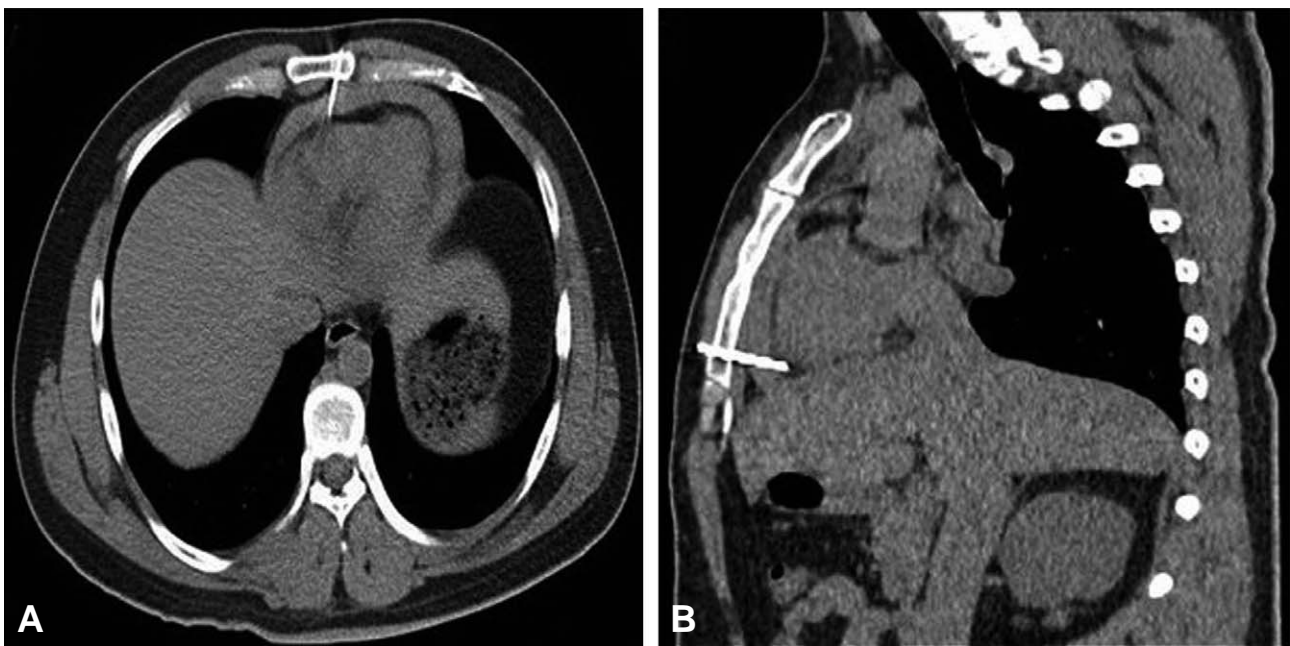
Noncontrast CT scan of the chest, axial source image (A) and sagittal reformatted image (B) reveal show that the nail has penetrated the heart wall and caused a pericardial effusion.
